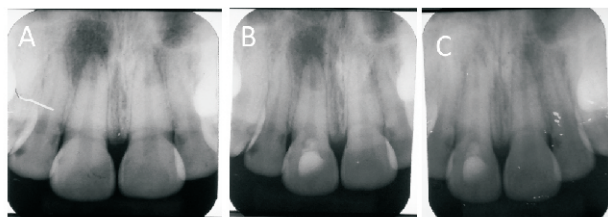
(A) Pre-treatment radiograph of the maxillary right central incisor showing a large well-defined periapical radiolucency at the apex. (B) Periapical radiographs obtained at the 6 months follow-up, shows evidence of healing after REPs. (C) Periapical radiograph obtained after 18 months, the periapical radiolucent lesion was completely healed. Tooth was asymptomatic and responded to pulp sensibility tests.
